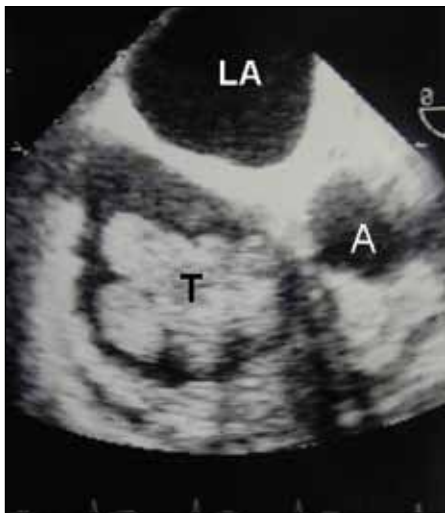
Transoesophageal echo image showing a lobulated tumour of dimensions 2.9 x 3.9 cm within the right atrium. A = aorta; LA = left atrium; T = tumour.
